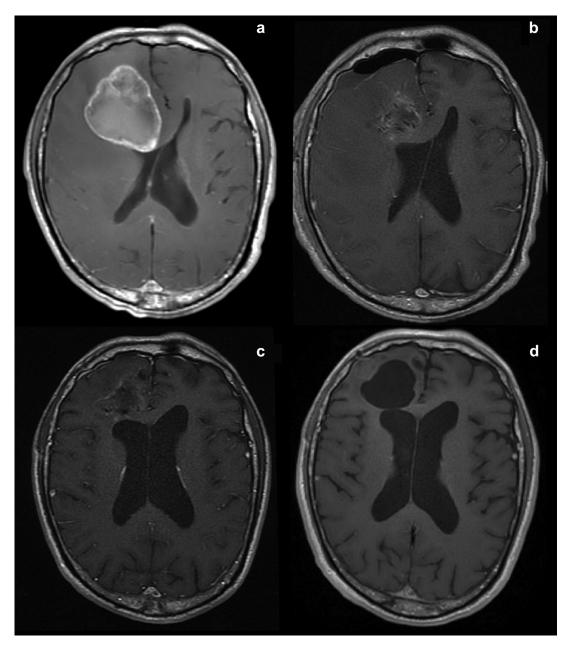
Preoperative and postoperative MRI images of the brain from axial T1-weighted contrast enhanced series. (a) 5.8-cm-diameter tumor 1 day before surgery. (b) Resection cavity with ¹³¹Cs seeds on postoperative Day 1 demonstrating proximity of seeds to the right lateral ventricle. (c) Resection cavity with ¹³¹Cs seeds on postoperative Day 54. (d) Resection cavity with ¹³¹Cs seeds on postoperative Day 219.
